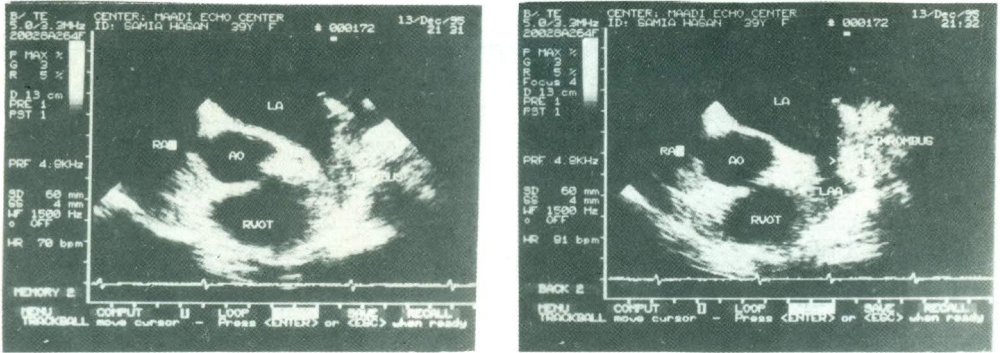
Transesophageal echocardiography basal short axis view demonstrating thrombus left atrial appendage.
